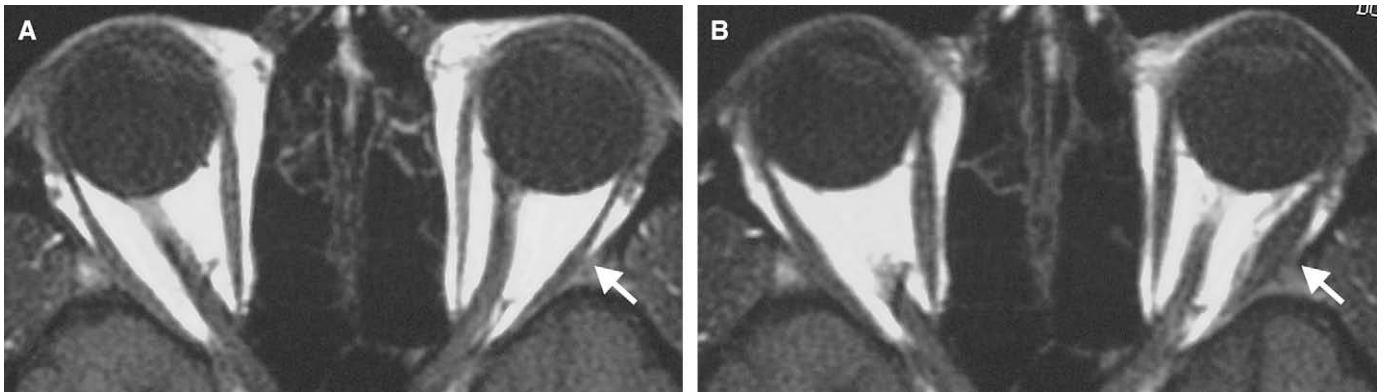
Axial MRI scans of Patient 5 injected with 1.0 mL of bupivacaine into the left lateral rectus: before injection (A) and 20 minutes after injection (B). Note the lack of bupivacaine in the important posterior third of the muscle.
